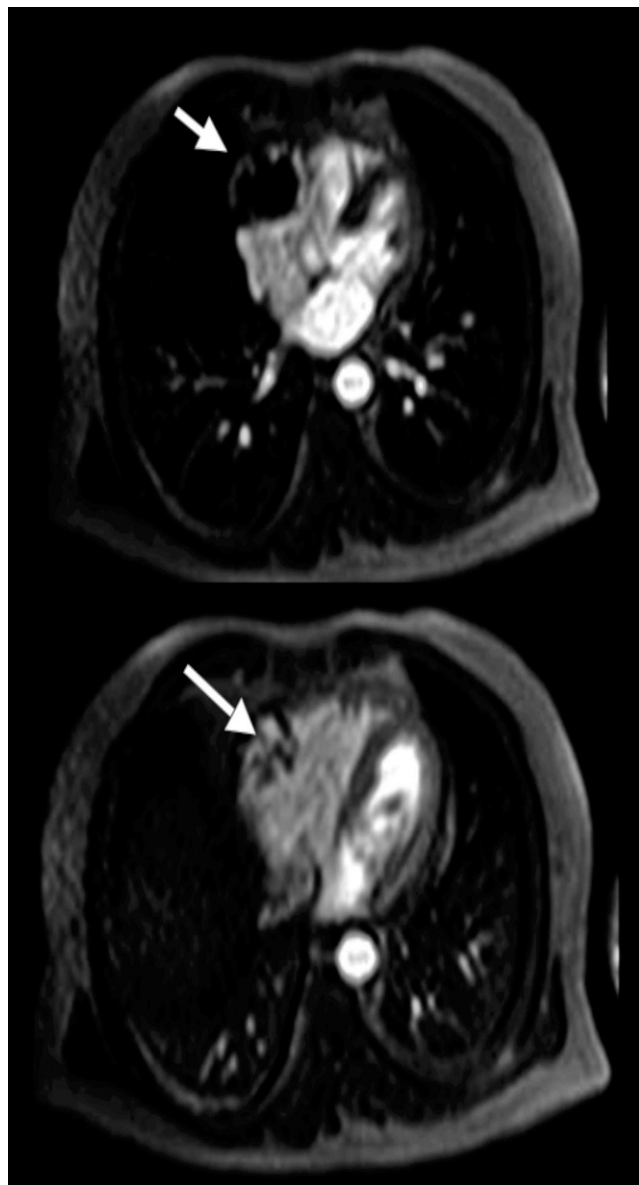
Case: 56-year-old male with new onset weight loss. Echocardiogram showed intracardiac mass. Cardiac magnetic resonance imaging: Without (top) and with (bottom) gadolinium. Diagnosis: Highly vascular structure with gadolinium; cardiac sarcoma (arrow).
